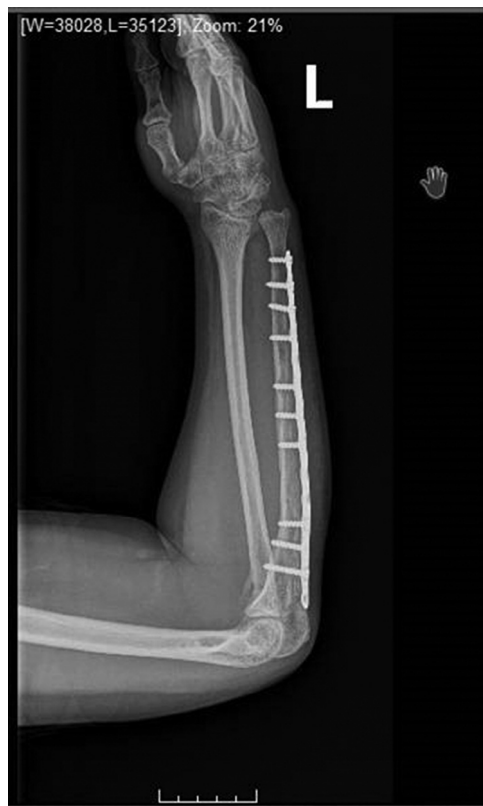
Lateral radiograph demonstrating reduction of the radiocapitellar joint and union of the ulna segmental fracture at 6 months postoperatively.
